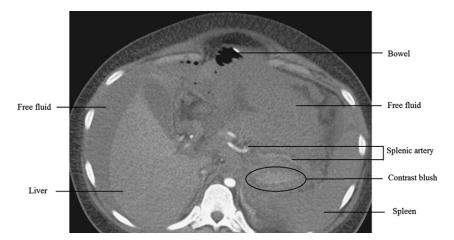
Contrast-enhanced abdominal computed tomographic angiography (transverse view) showing free fluid around the liver and retroperitoneal space with active contrast blush originating from the splenic artery, representing arterial extravasation.
